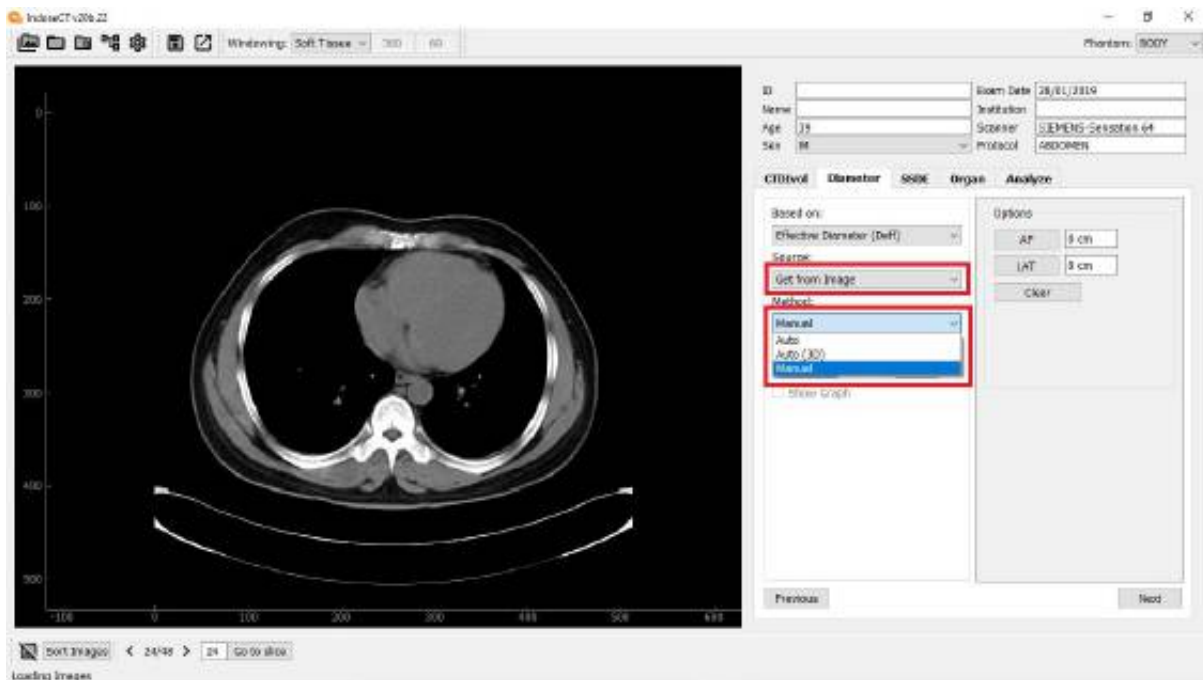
D_{eff} calculation from the image. There are three choices of methods, namely: Manual, Auto, and Auto (3D). When the user uses the Get From Image option menu, It must have opened the patient's CT image in DICOM format.
